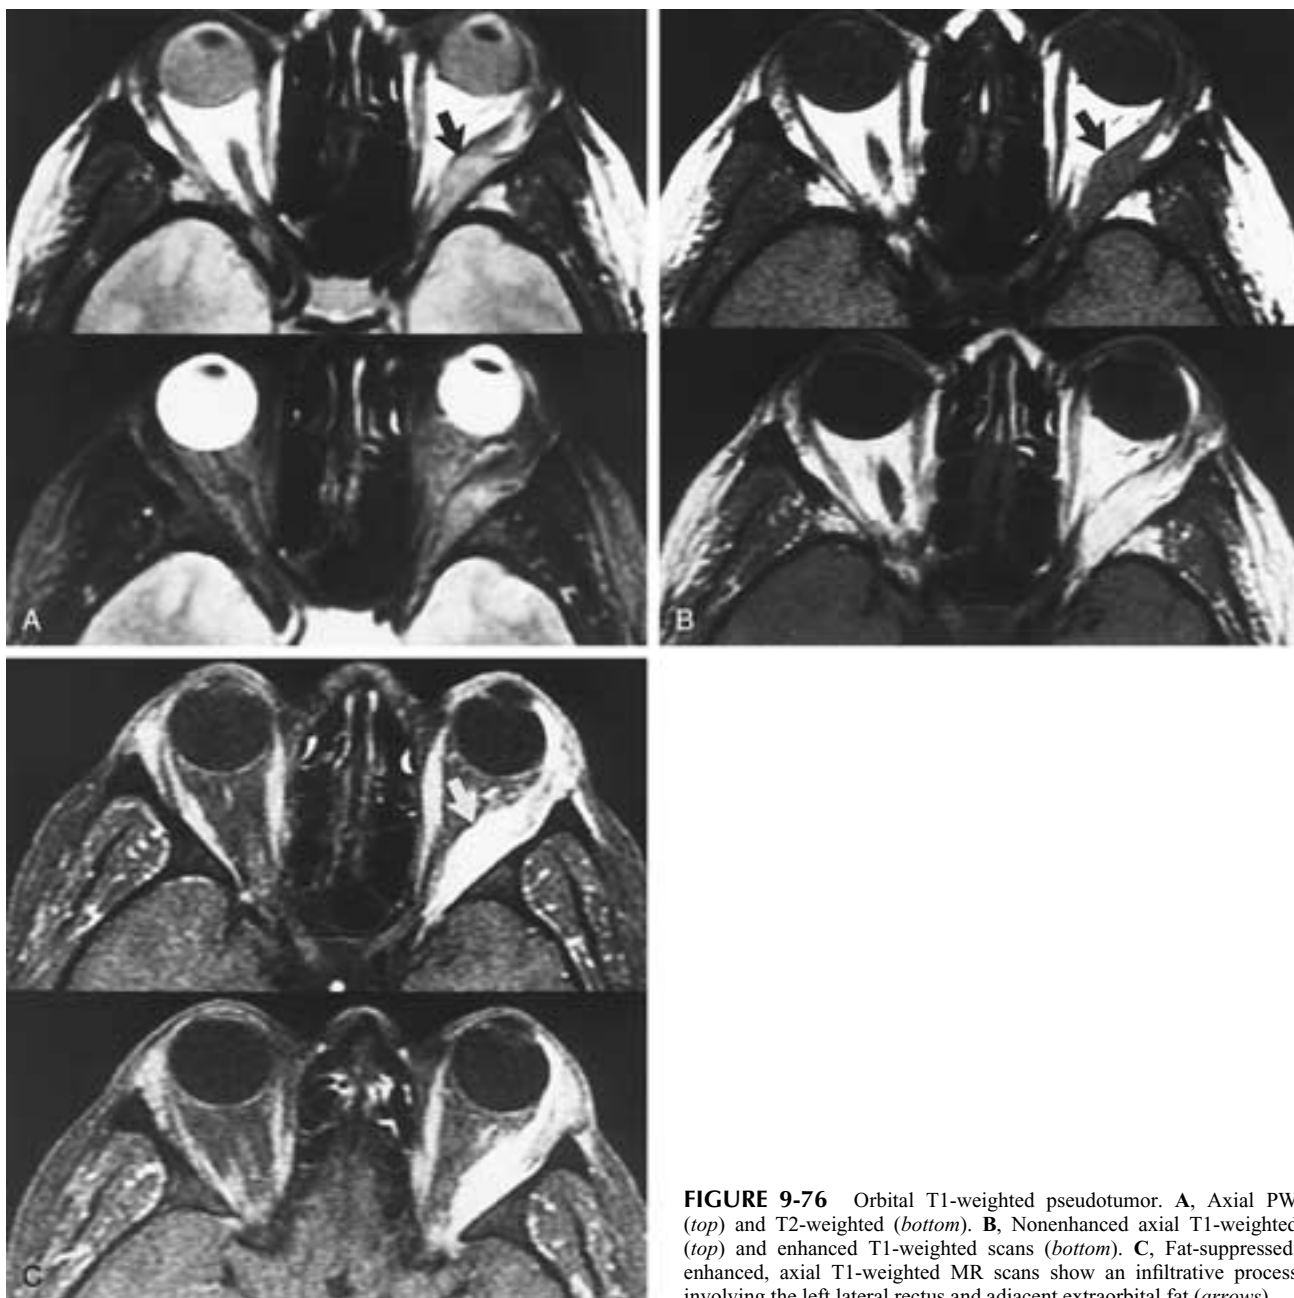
Orbital T1-weighted pseudotumor. A, Axial PW (top) and T2-weighted (bottom). B, Nonenhanced axial T1-weighted (top) and enhanced T1-weighted scans (bottom). C, Fat-suppressed, enhanced, axial T1-weighted MR scans show an infiltrative process involving the left lateral rectus and adjacent extraorbital fat (arrows).
